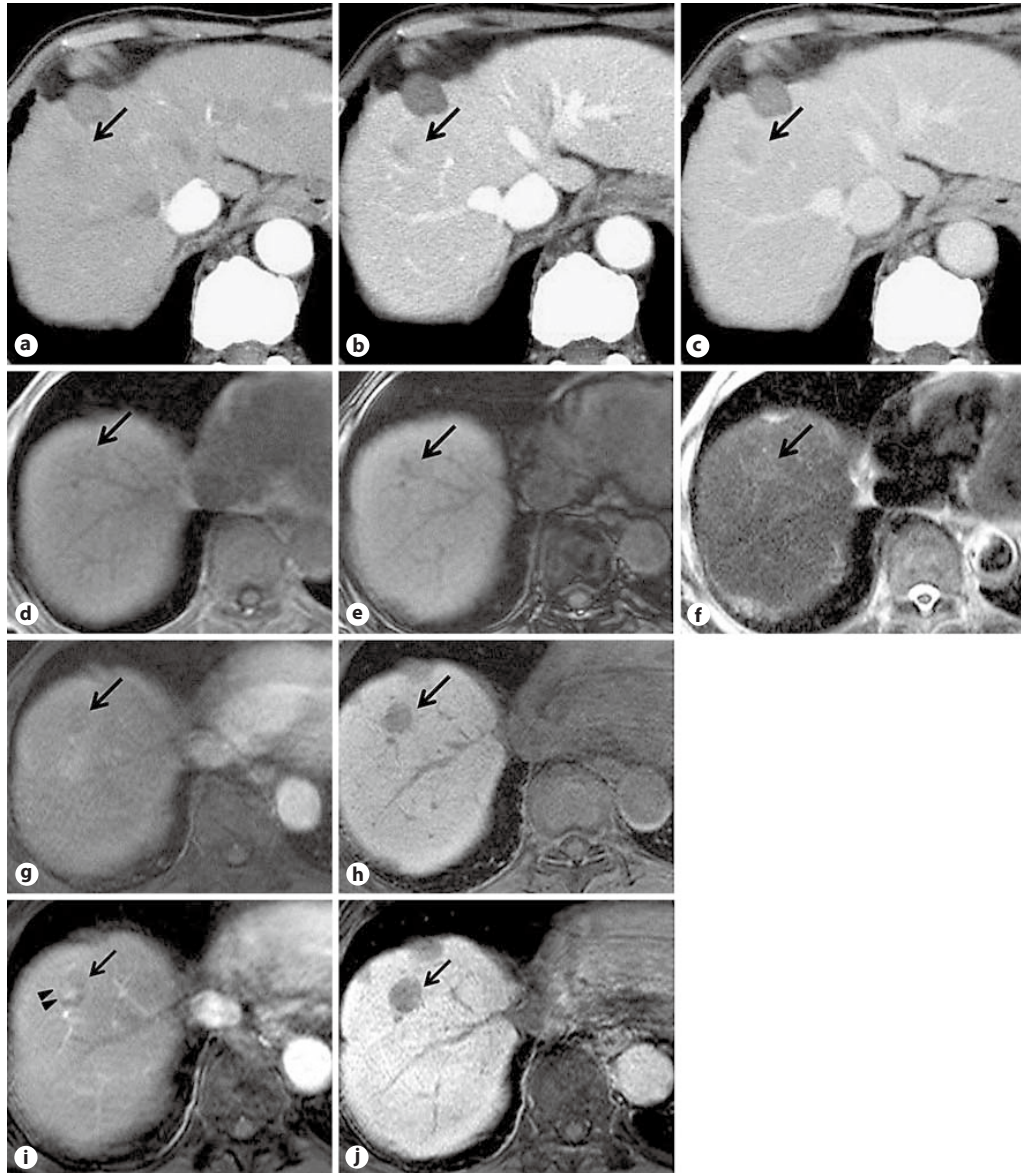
A 79-year-old man with hepatitis C-related cirrhosis. a–c Initial dynamic CT. The hepatic nodule in segment 8 of the liver showed no contrast enhancement (arrow). d–e Initial Gd-EOB-DTPA-enhanced MRI. The nodule showed fat deposition on chemical-shift imaging (arrow, in-phase, d; out-of phase, e). On T2-weighted imaging, the nodule showed slight hyperintensity (arrow, f). Images for the arterial phase (arrow, g) and hepatobiliary phase (arrow, h) of Gd-EOB-DTPA-enhanced MRI at the start
